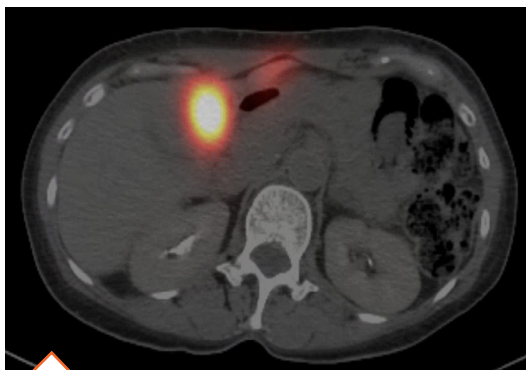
SPECT-CT following mapping procedure shows intense uptake of Tc-MAA in segment 4 tumor.
